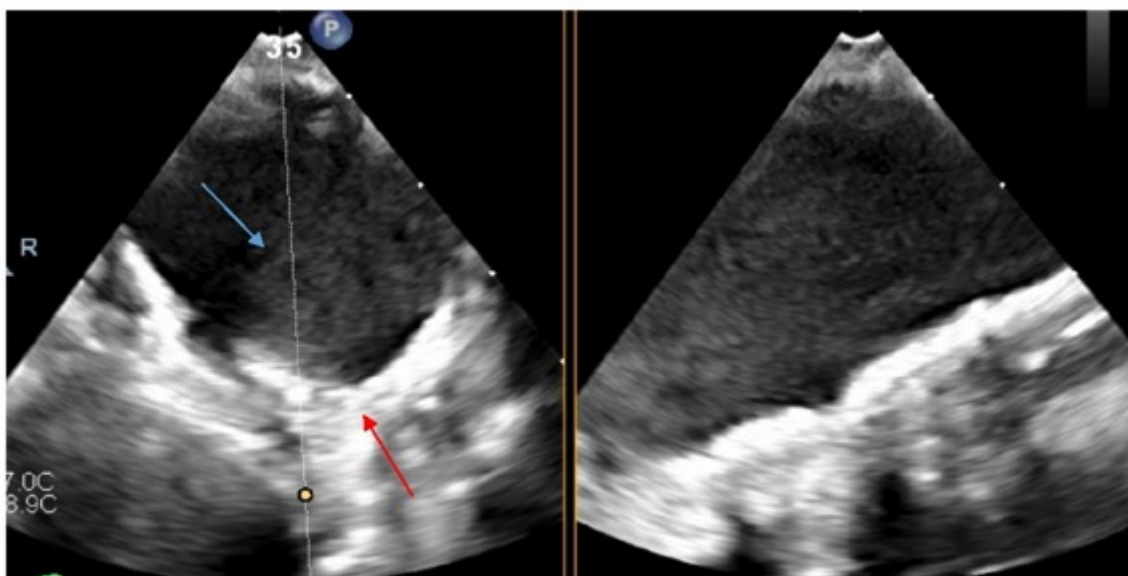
TEE of ascending thoracic aorta showing calcified aortic atheroma (red arrow) with adjacent swirling pattern of aortic spontaneous echocardiographic contrast/SMOKE (blue arrow).
